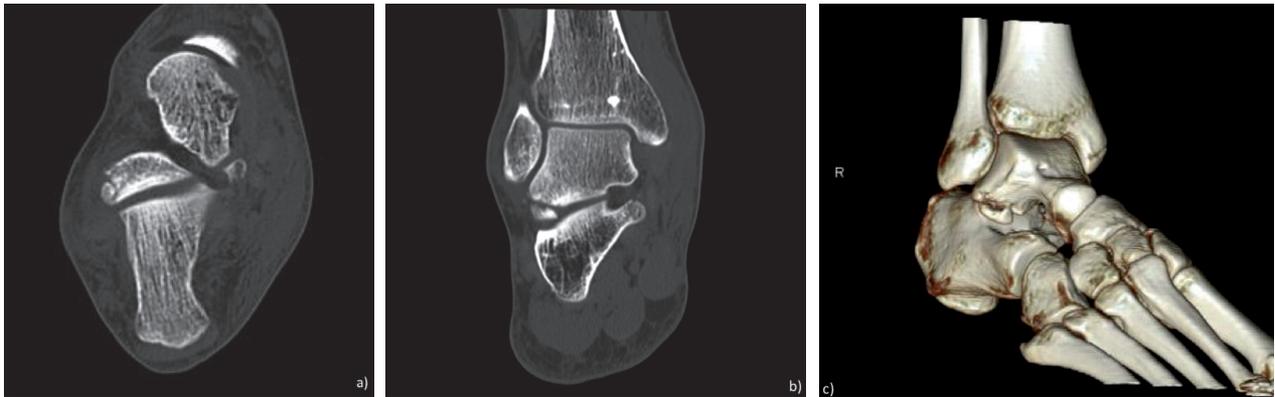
Comminuted lateral process fracture. AP radiograph (A), coronal CT MPR (B) and VRT reconstruction (C)
